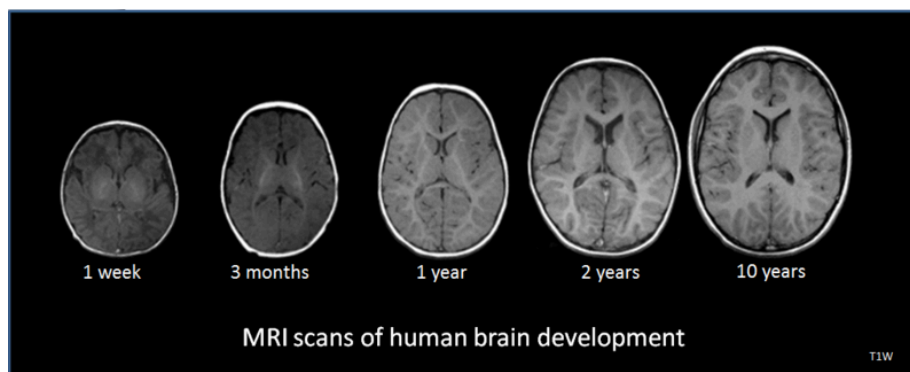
MRI scans of the human brain.¹¹
